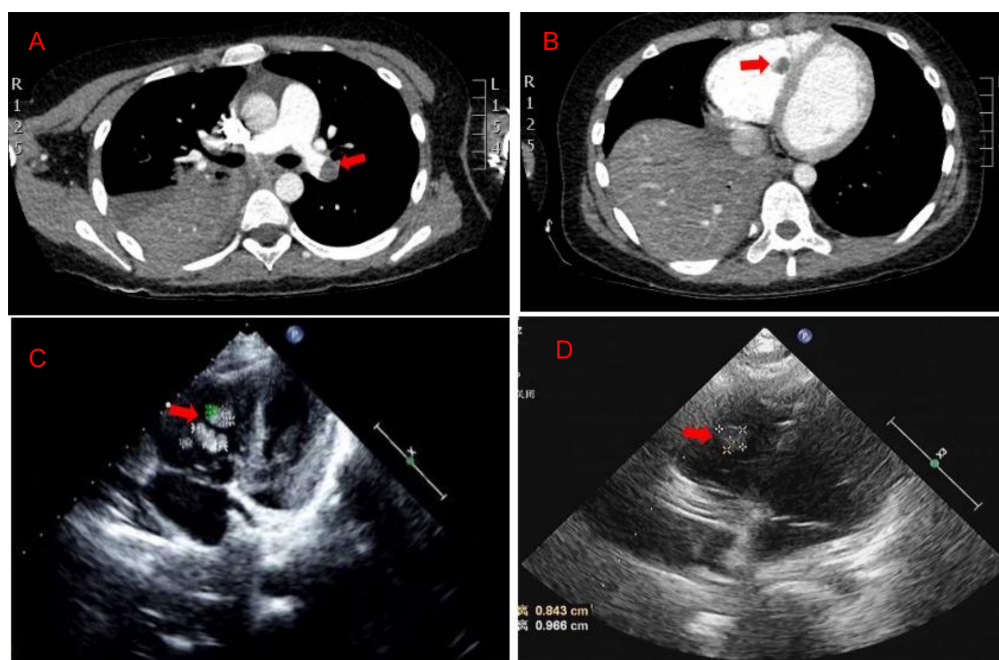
(A,B) The chest CT angiography showed a filling defect in the left lower pulmonary artery and right ventricle. (C) Echocardiography revealed multiple mass echos in the right ventricle (4×3 mm, 13×5 mm, and 9×5 mm) on day 3. (D) Echocardiography revealed mass echos in the right ventricle (8×13 mm) on day 12.
